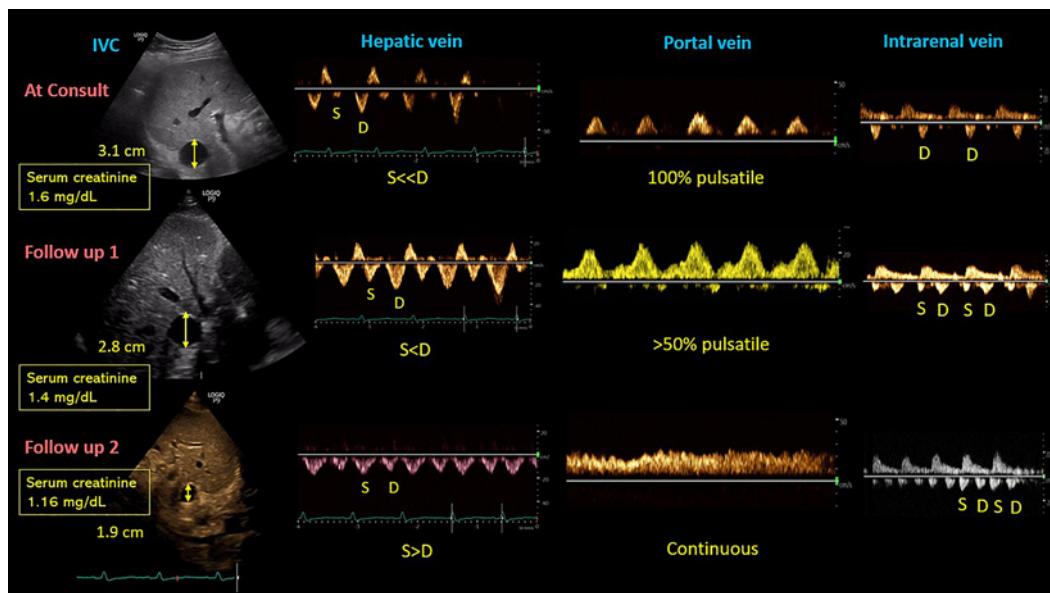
IVC (transverse view) and VExUS (venous excess Doppler ultrasound) findings at the time of nephrology consultation and follow-up examinations.
